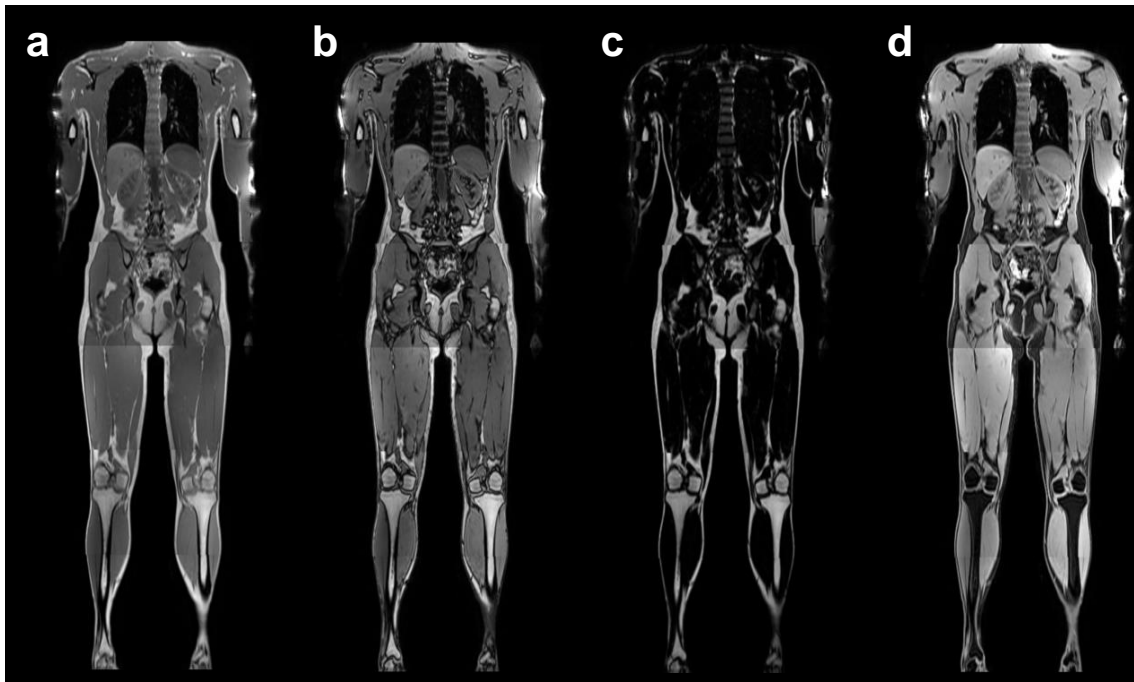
Example of two-point Dixon MRI. Whole-body two-point Dixon MRI of a 31-year-old man. In-phase (a) and opposed-phase (b) images are acquired and used to calculate fat- and water-selective images. The fat-selective image (c) results from the subtraction of in- and opposed-phase images, in contrast to the water-selective image (d) resulting from addition.
